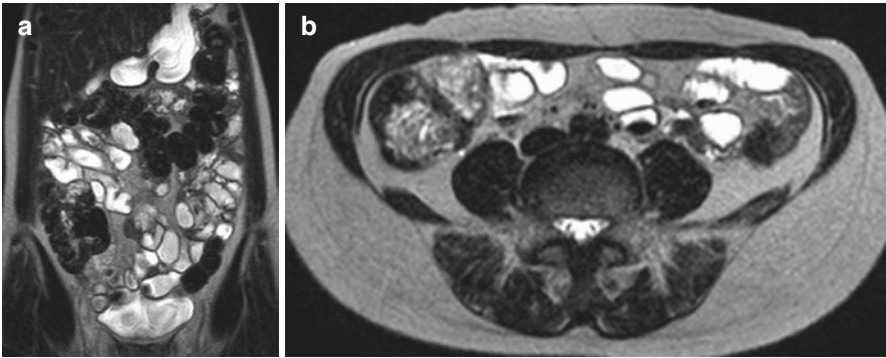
Coronal (a) and axial (b) heavily T2-weighted images obtained with an effective echo time of 200 ms. This series is ideally performed before gadolinium administration and without fat suppression
